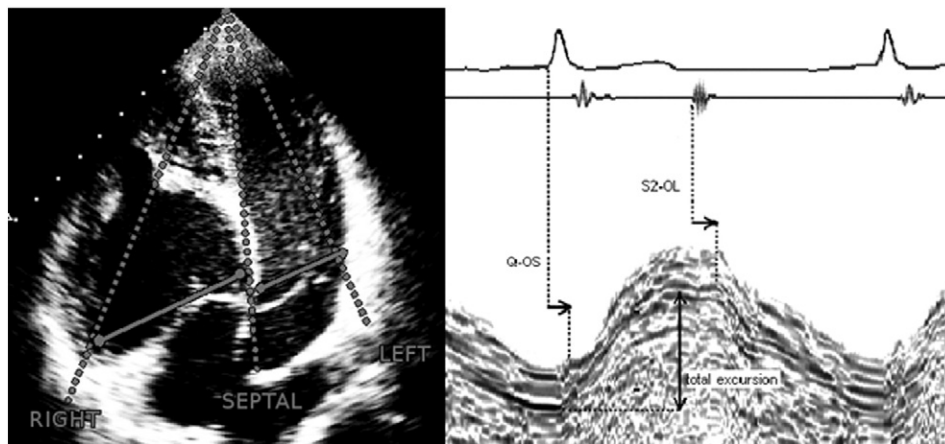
The left panel shows M-mode recording of pulmonary, septal and systemic ventricular long-axis excursion and 2D-measurement of the inflow tract diameters of the pulmonary and systemic ventricle from the apical 4-chamber view. The right panel shows M-mode recording of long-axis motion. Q-OS, time from q to onset of shortening; S2-OL, time from second heart sound to onset of lengthening.
